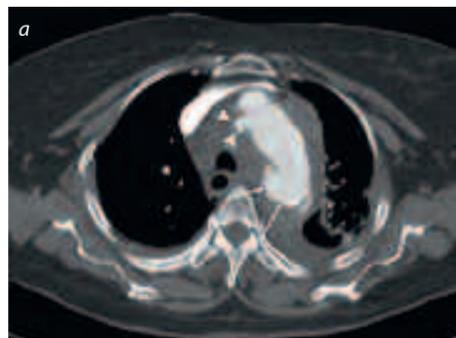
Traumatic Aortic Injury treated by Complete Arch Debranching and Endografting. (a) Two level injury to the aortic arch with trauma to the anterior (arrowheads) and posterior (arrows) aortic arch. (b) CT after full debranching of the aortic arch and endografting.
